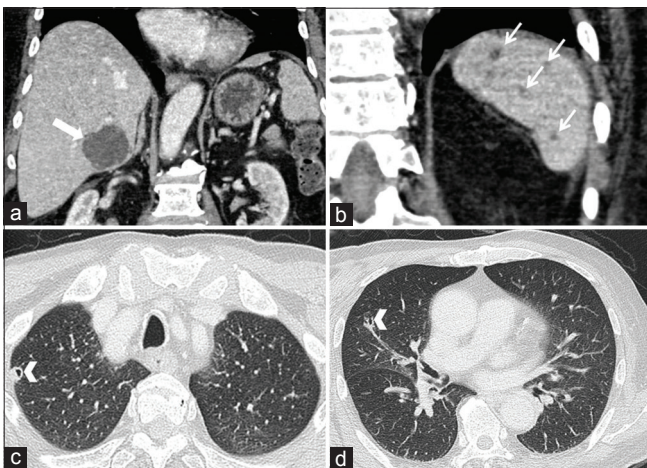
(a) Contrast-enhanced computed tomography scan of the abdomen revealed a segment VI liver abscess (bold white arrow), (b) with multiple small abscesses in the spleen (narrow white arrows). (c and d) Cavitating lung lesions were observed in the upper and middle lobes of the right lung (arrowheads)
